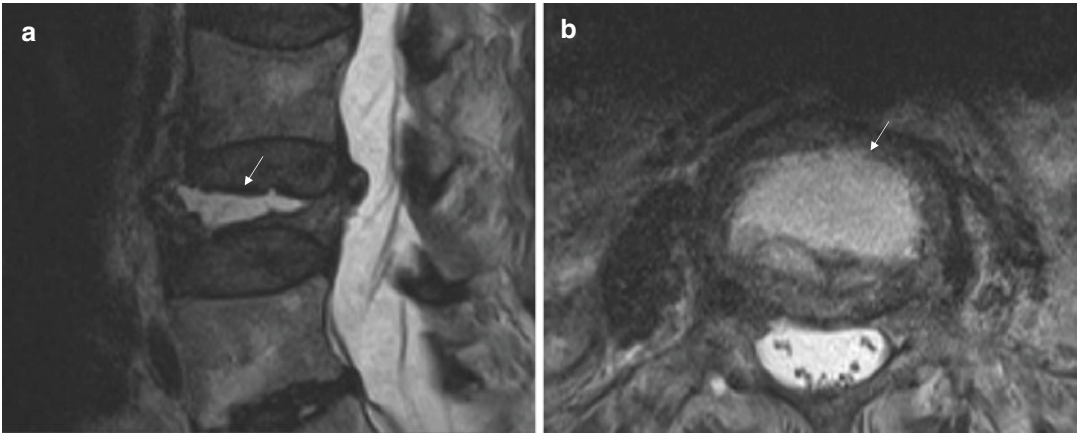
(a) Sagittal and (b) axial T2-weighted images demonstrate intravertebral cleft or fluid sign at L4, compatible with benign osteoporotic burst fracture (white arrows)
